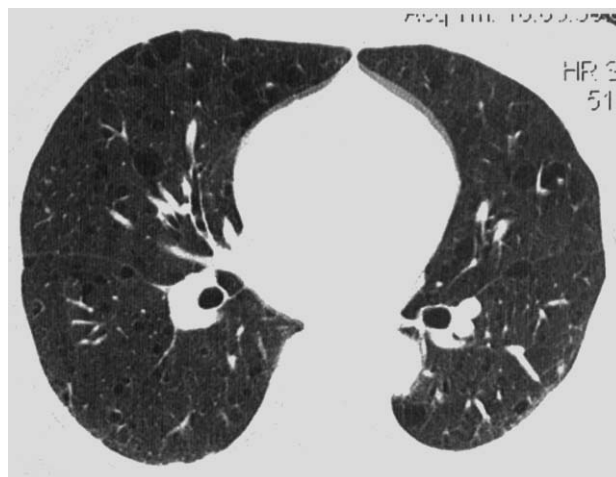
Chest CT scan demonstrating innumerable thin-walled cysts of varying sizes randomly distributed throughout the parenchyma of both lungs.
